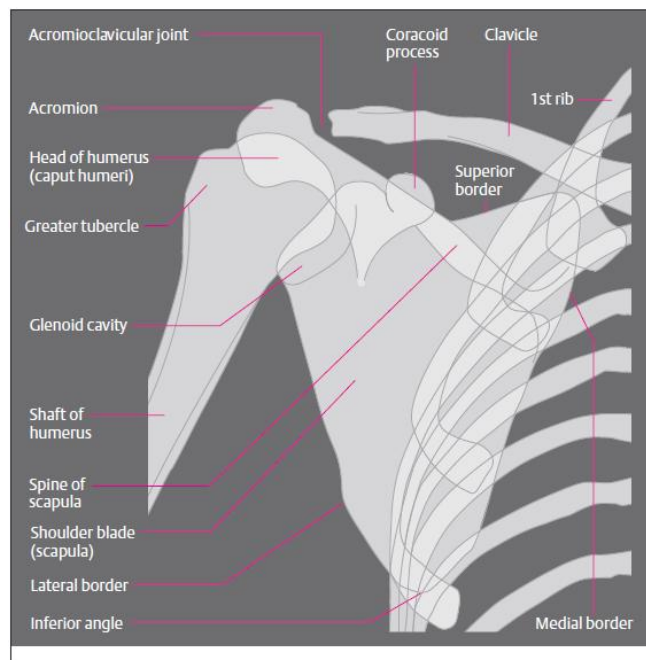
Simplified tracing of a radiographic image, anterior view
